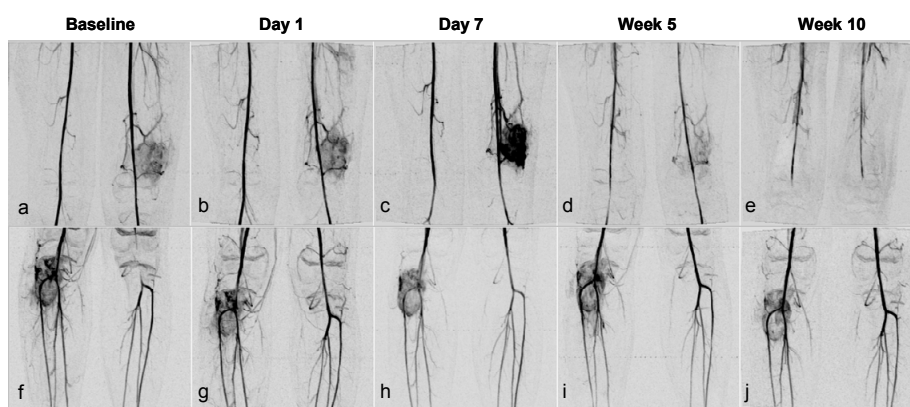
DCE-MRA MIP images from Phase II of the five longitudinal DCE-MRI exams for two patients (a responder: upper row; a nonresponder: bottom row). Each row is in the same gray scale.
